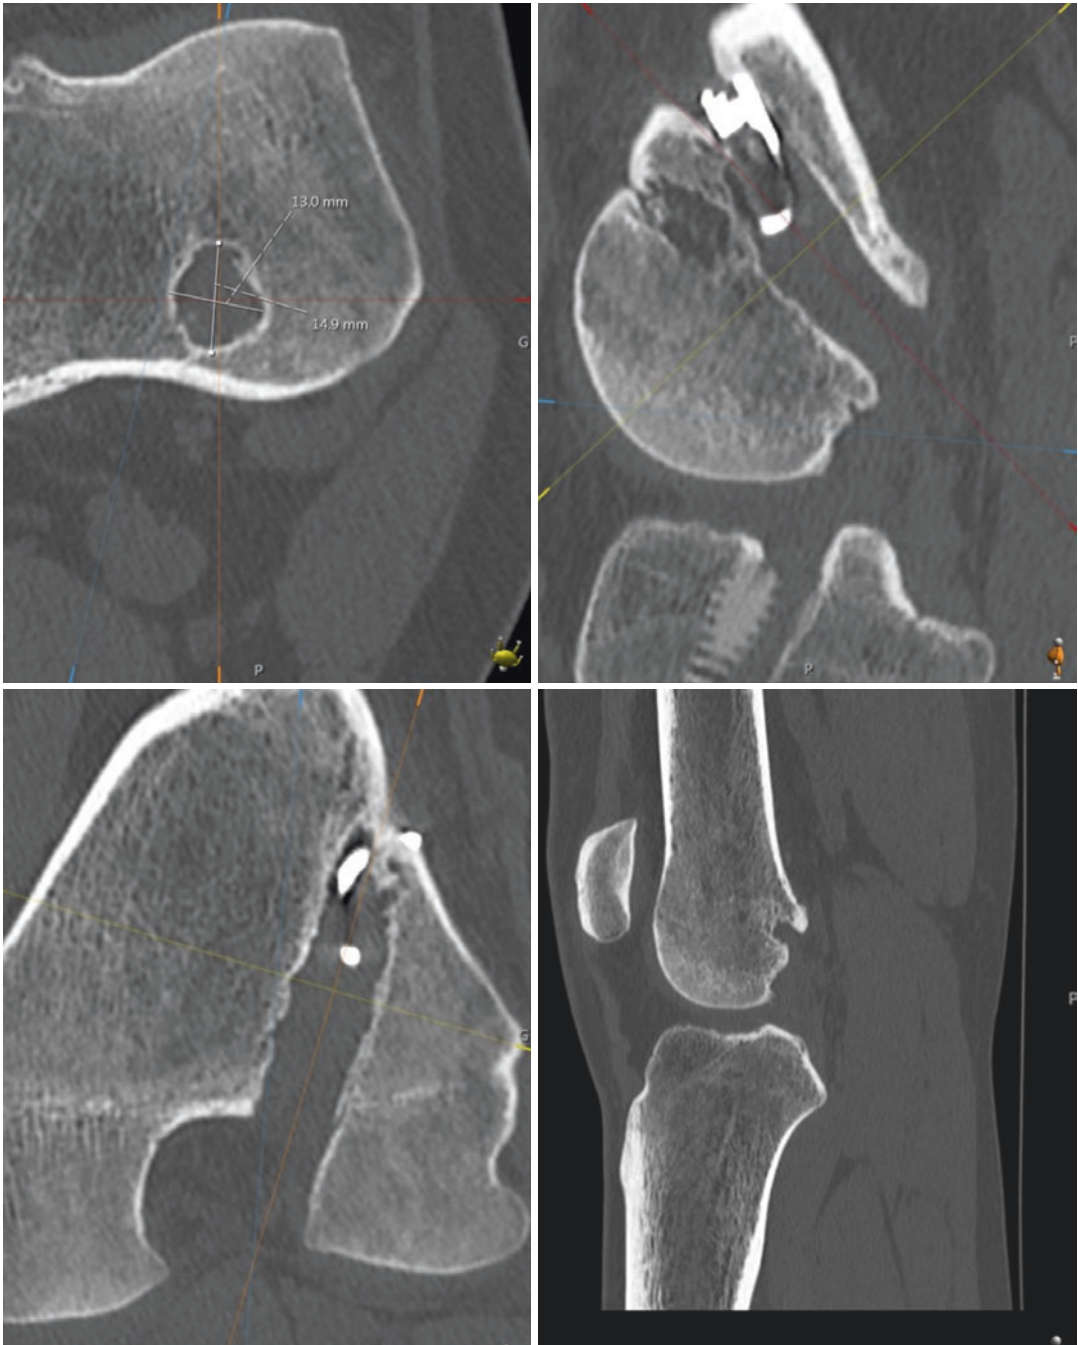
CT image is able to provide more detailed information about bone tunnel enlargement
